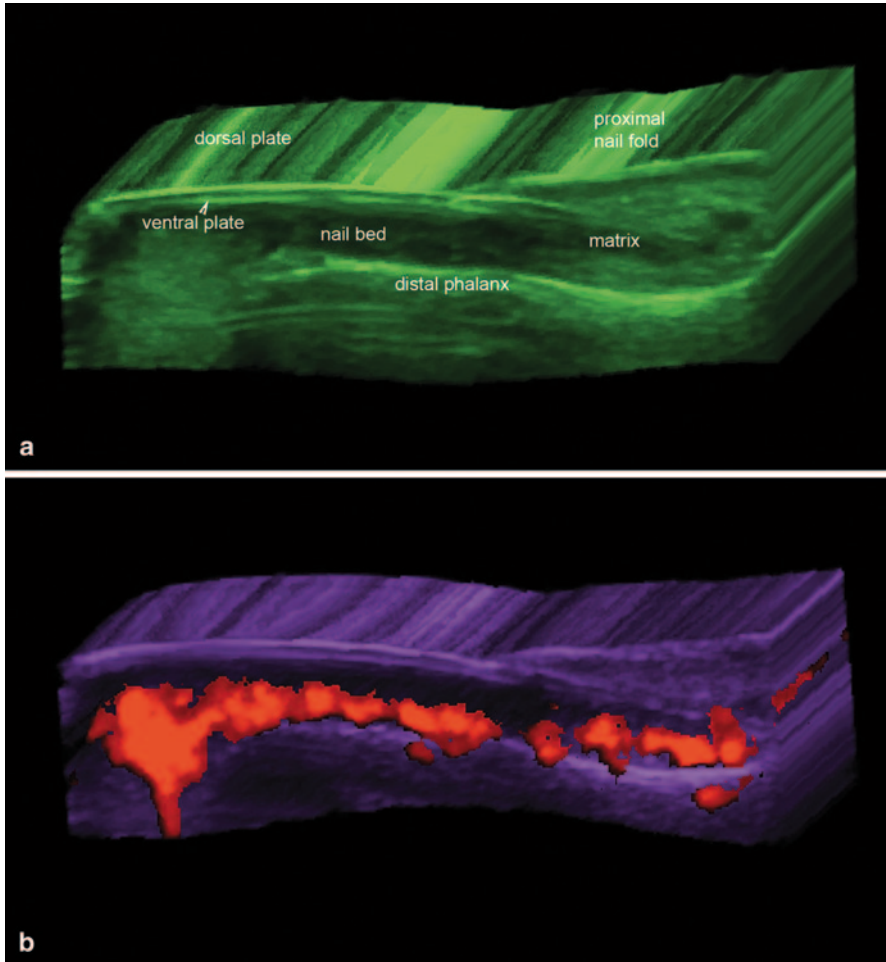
Sonographic anatomy of the normal nail. a, b 3D reconstructions (a: gray scale and b: power Doppler; longitudinal views, index finger; color filter) show the parts of the nail unit (a) and the ungual vessels (b), in color)
